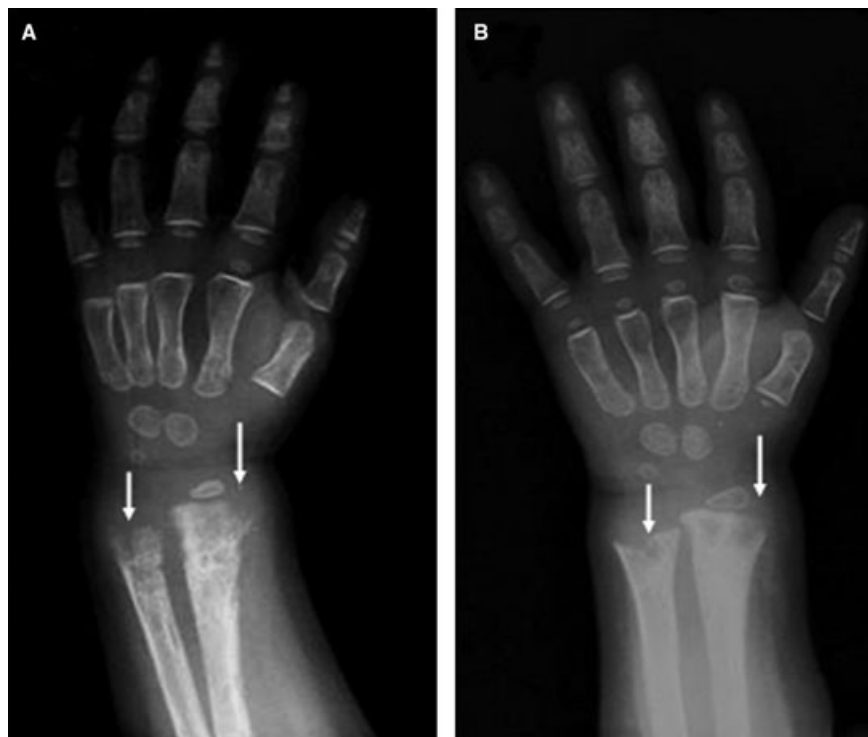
Radiograph of the left wrist and arm showing tongues of radiolucency (arrows) in distal metaphysis of radius and ulna before (A) and after low calcium diet (B).
